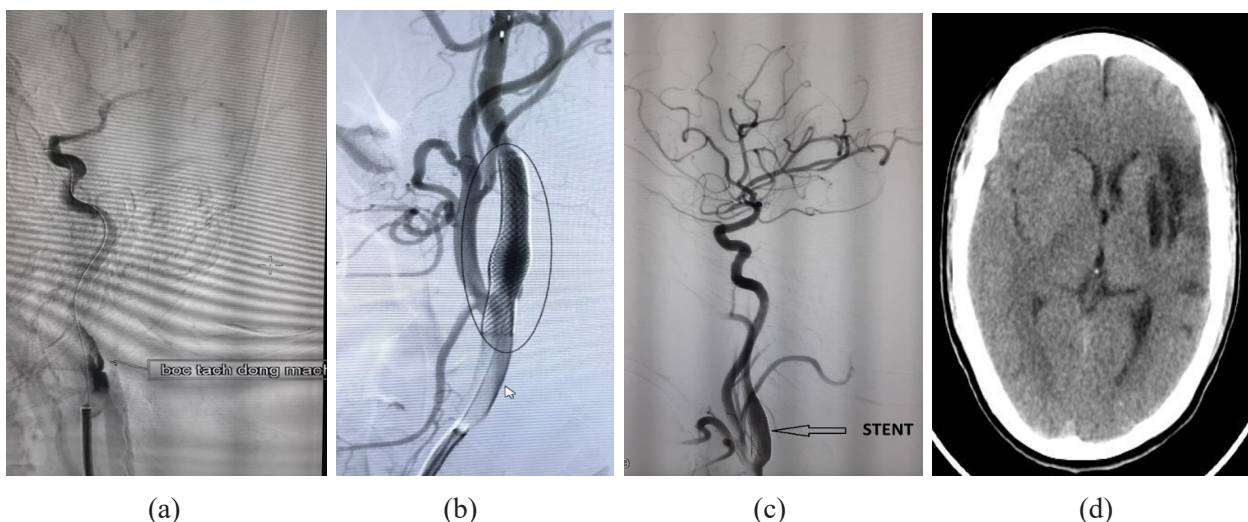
(a) Angiogram shows a dissection left carotid artery. (b) Deployed Stent. (c) After stenting, the vessel is recanalized to a TICI 3 state. (d) Control CT scan shows right hemispheric striatocapsular infarction and multiple parietal small embolic infarctions. At 3 months, the patients had a good outcome.
